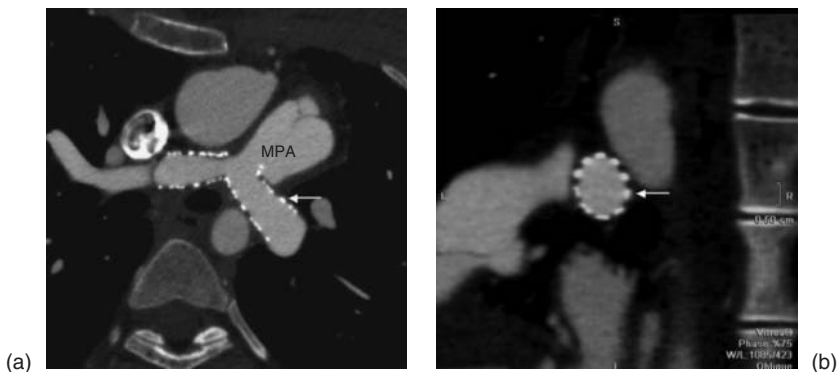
Contrast-enhanced computed tomography double oblique projection of the branch pulmonary arteries demonstrating pulmonary artery stents (arrow) in long (a) and short axis (b).
